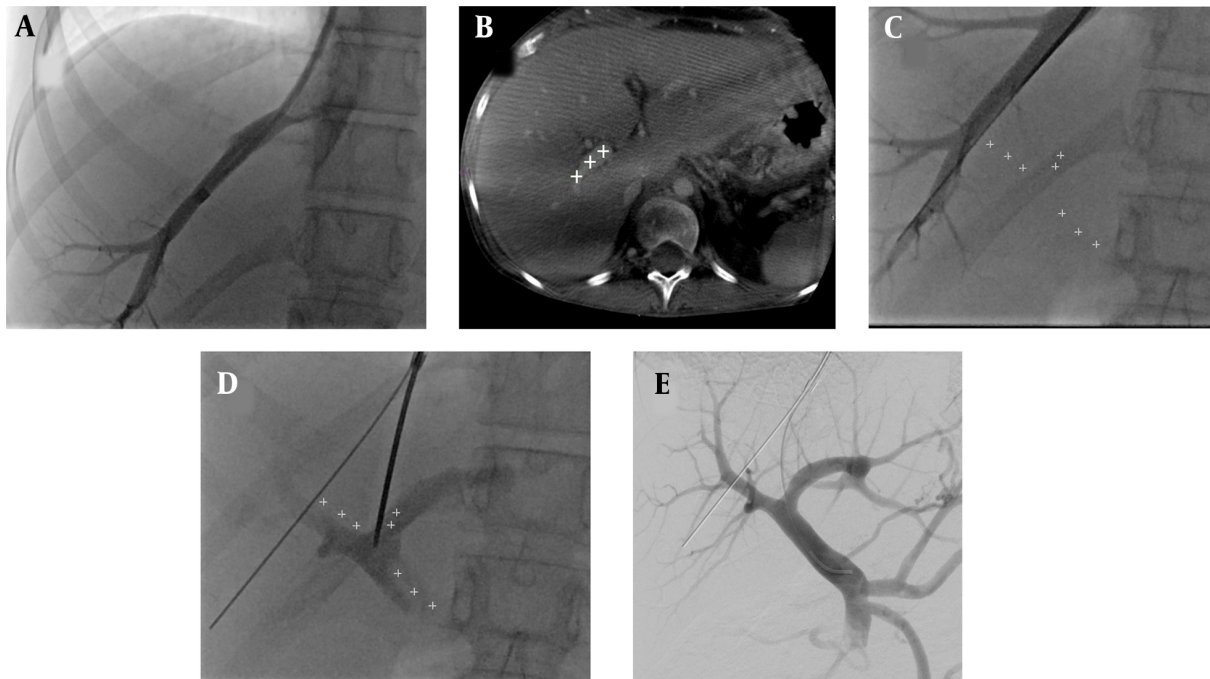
A, Hepatic venogram; B, Based on three-dimensional cone-beam computed tomography (3D-CBCT), the portal vein was marked; C, After 3D mapping of the right portal vein branch in C-arm CT, the annotated portal vein branches were overlaid on the real-time fluoroscopic image; D, After puncture of the portal vein, the contrast medium was injected to confirm successful puncture; E, Portography shows the patent portal vein with hepatopetal flow and retrograde filling of the splenic and inferior mesenteric veins.
